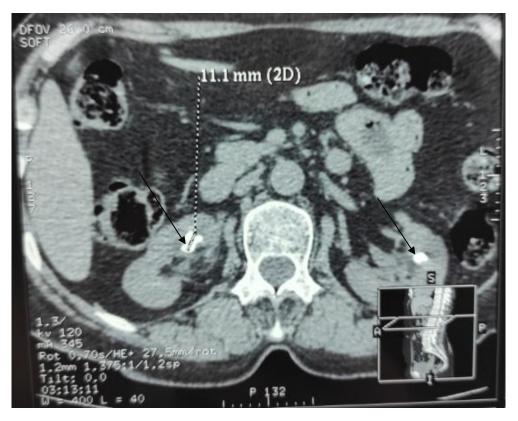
Axial CT scans showing bilateral renal lithiasis
